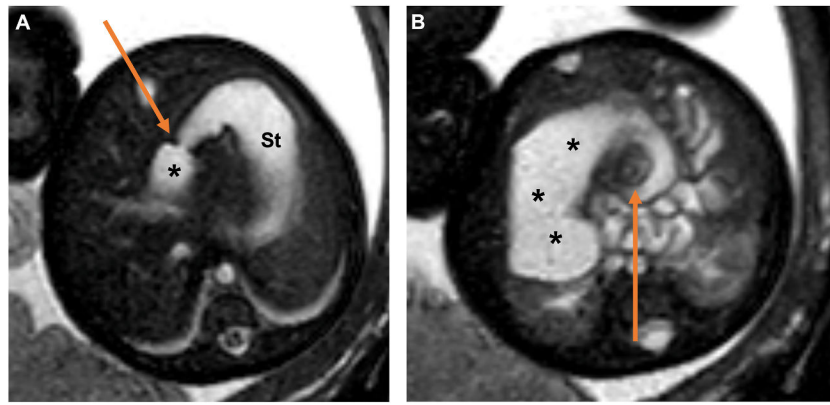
Axial balanced turbo field-echo fetal magnetic resonance images at 33 weeks, 4 days demonstrate A) a widely open pylorus (arrow) with dilation of the stomach (St) and B) duodenum (asterisks), abruptly tapering as they swirl around the superior mesenteric vascular pedicle (arrow).
